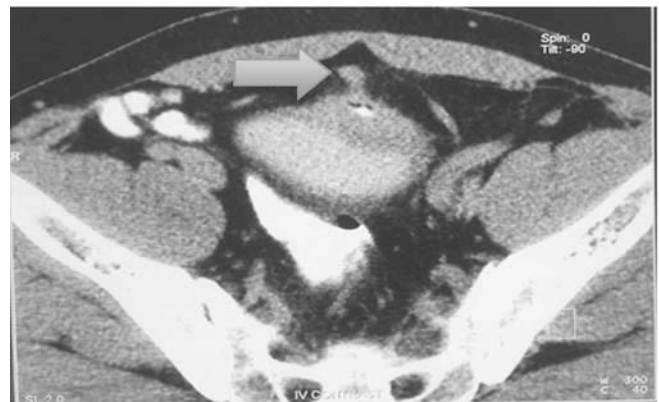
Axial view of the whole abdominal CT scan with oral contrast of the patient showing the fistulous connection (arrow) between the sigmoid colon and the anterior portion of the bladder. The bladder shows contrast enhancement.
